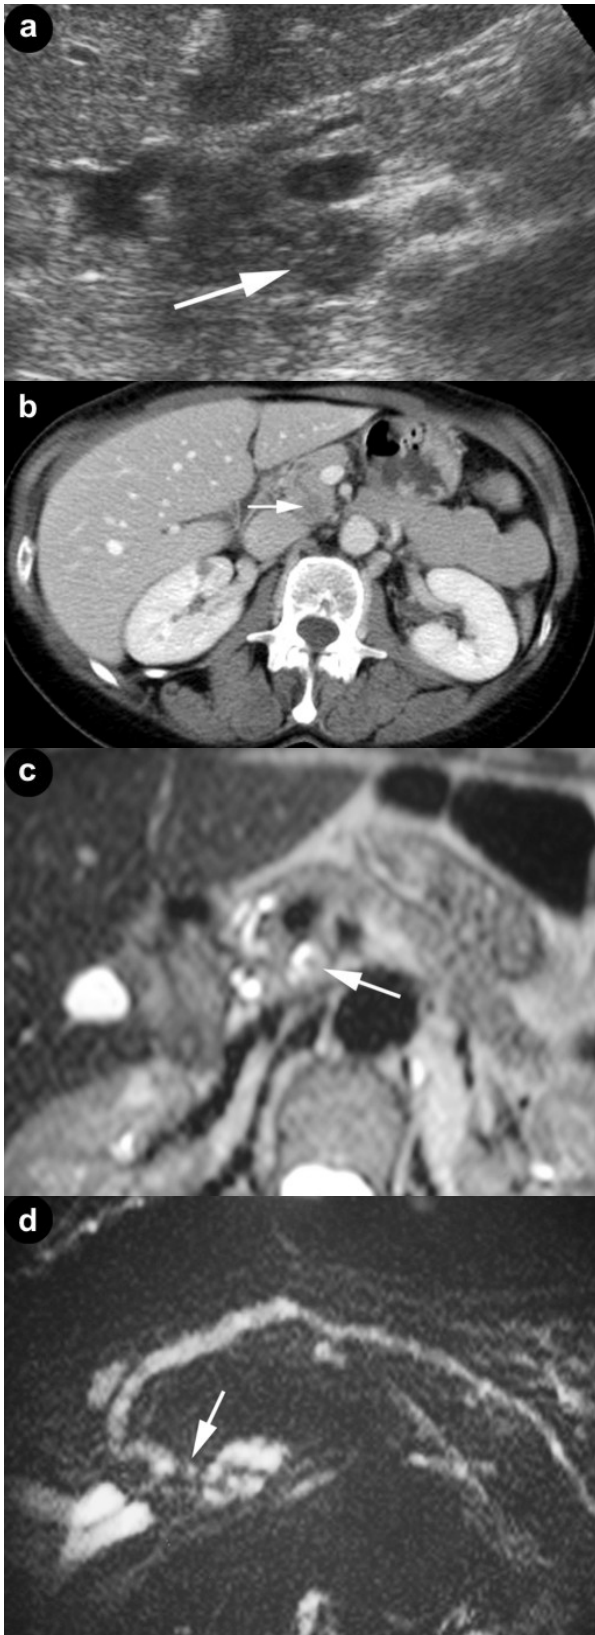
Wrong diagnosis of IPMN at imaging. a. Ultrasound examination revealed the presence of a small microcystic lesion (arrow) of the pancreatic uncinus process with solid intralésional tissue and a slight dilation of the main pancreatic duct. b. At CT the lesion (arrow) was confirmed with a cystic appearance. MRI also confirmed the cyst which contained a small intralésional nodule (c. arrow) communicating with the main pancreatic duct (d. arrow). Moreover, a slight dilation of the main pancreatic duct was documented.
